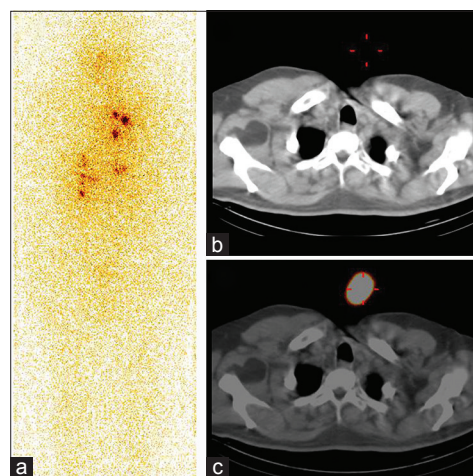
Pretherapy I-131 planar whole-body anterior view image (a) of a 64-year-old male patient with papillary thyroid cancer demonstrated multiple foci of tracer uptake projected over the chest and abdomen, which could be due to lung and liver metastases. Transaxial CT (b) and corresponding transaxial fused single photon emission computed tomography/computed tomography (SPECT/CT) images (c) of chest localizes the tracer uptake outside the body confirming these as surface contamination. In this case, SPECT/CT avoided unnecessary treatment of the patient
